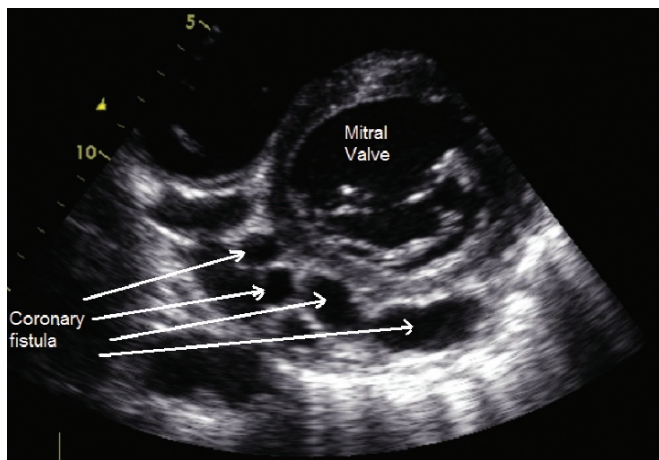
Transthoracic echocardiographic parasternal short-axis view showing abnormal vessels on the posterior surface of the left ventricle.
